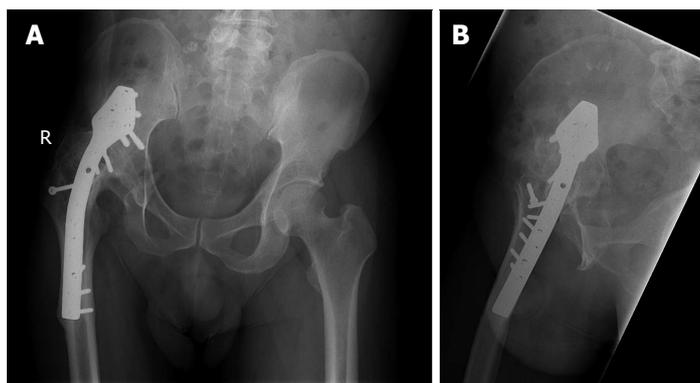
Initial Radiographs at presentation which shows stage III tuberculous arthritis (A) and screw loosening on the right hip (B).
